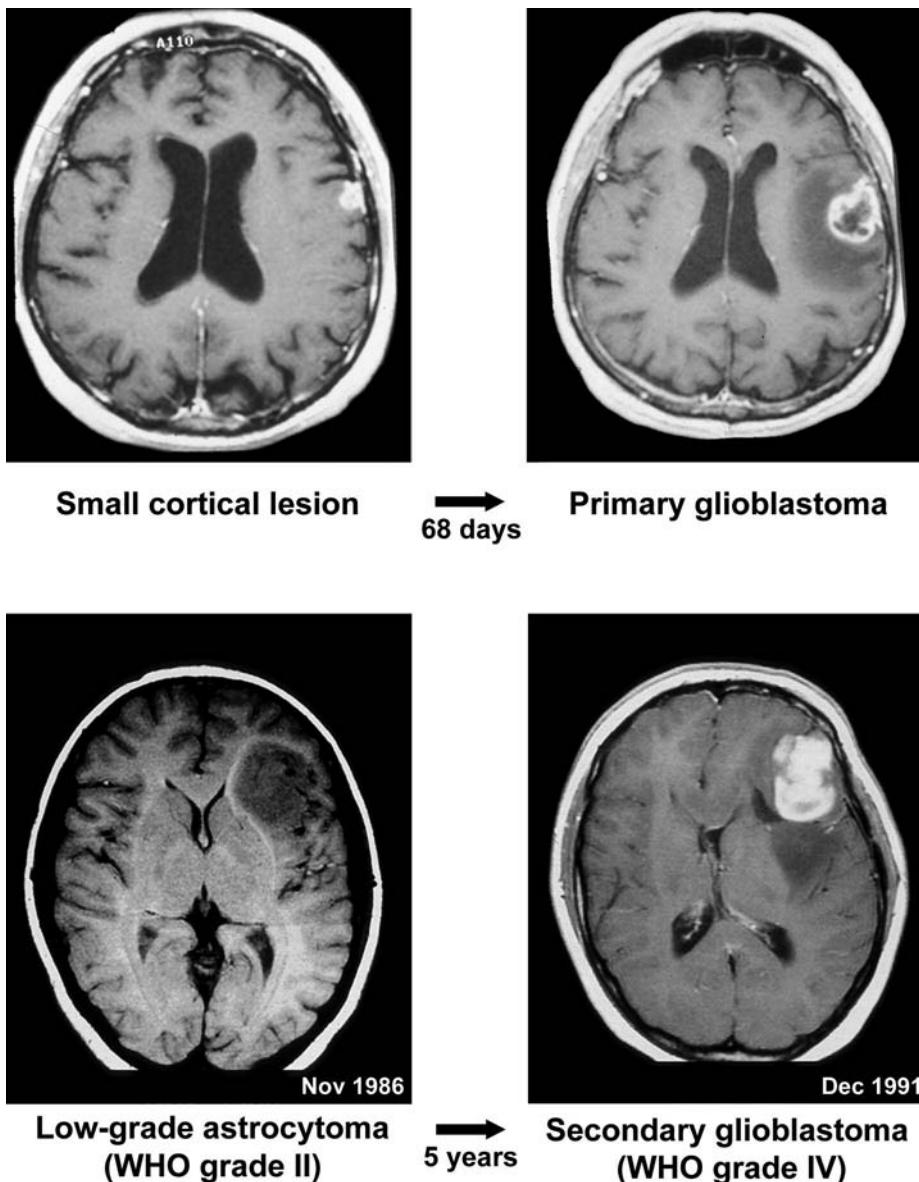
Rapid evolution of a primary glioblastoma in a 79 year-old patient (upper). MRI shows a small cortical lesion that within 68 days developed into a full-blown glioblastoma with perifocal edema and central necrosis. This is in contrast to the development of secondary glioblastoma through progression from low-grade astrocytoma (lower).
